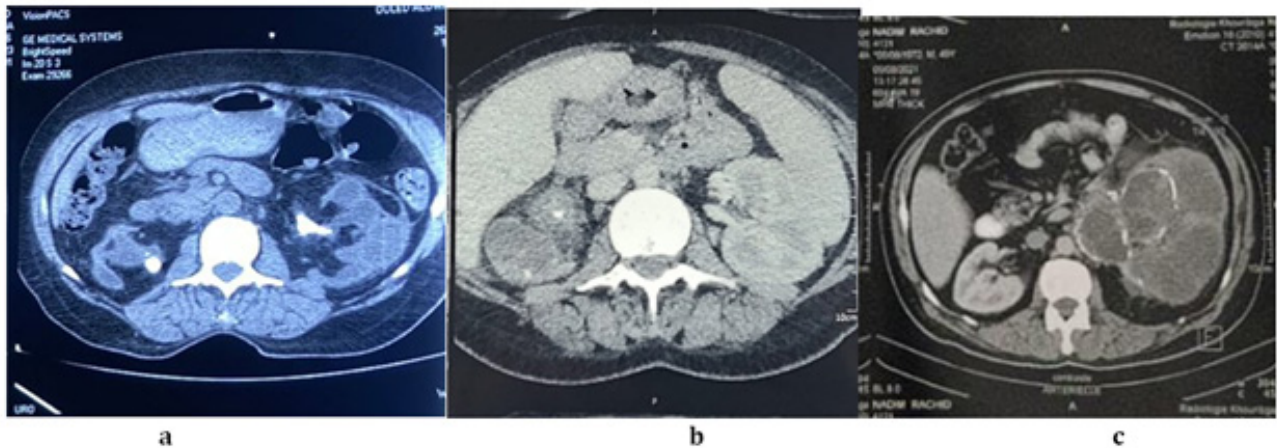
CT images of pyonephrosis due to pyelic lithiasis (a,b) and to ureteropelvic junction (c).
